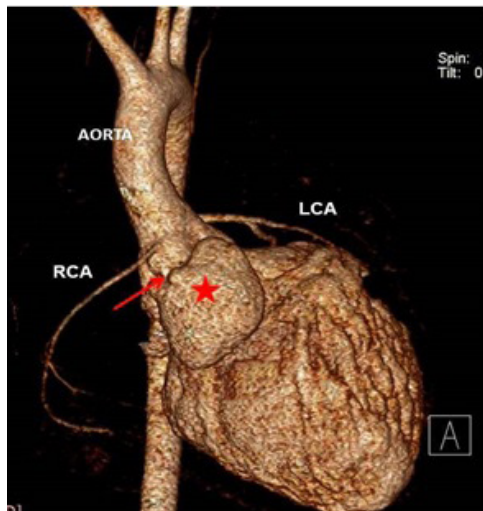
Three dimensional reconstructed computed tomography image of the left ventricle and the aorta. The sinus of Valsalva aneurysm is seen (*) arising just below the origin of the right coronary artery (indicated by the closed arrow). The coronaries were normal. Abbreviations: RCA – right coronary artery, LCA – left coronary artery.
